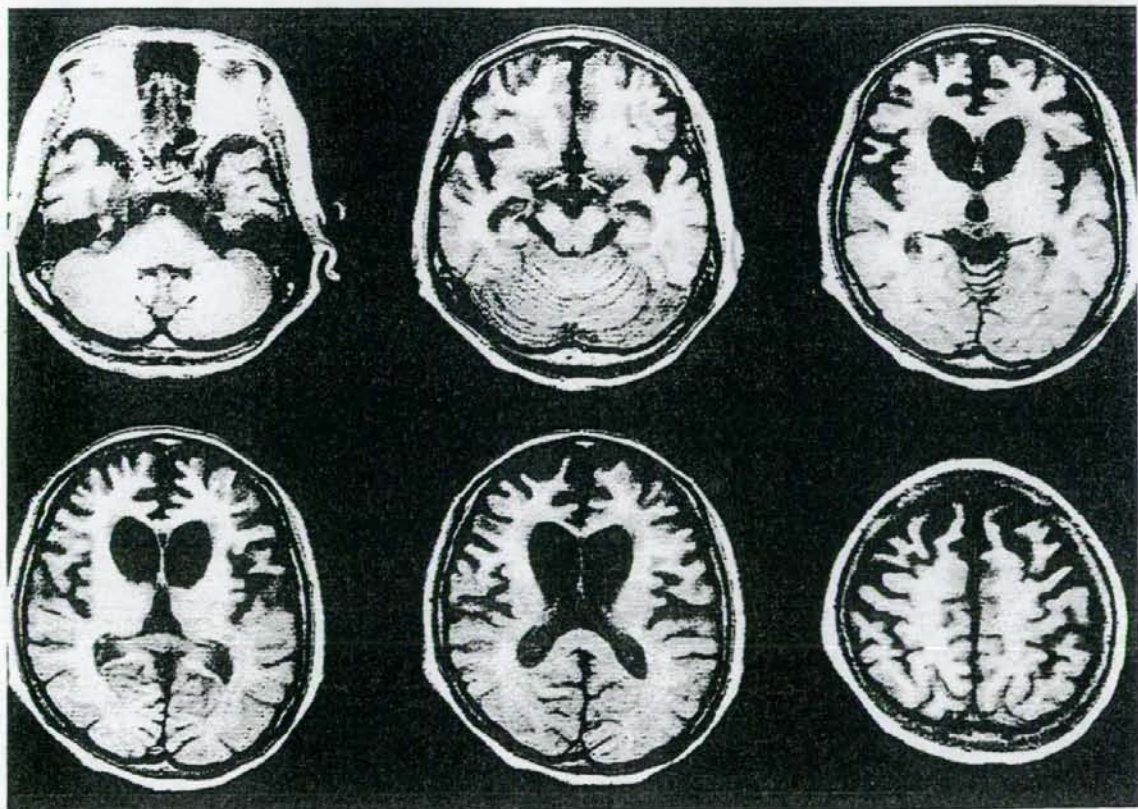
MRI performed about 1 year after the first admission. Prominent atrophy of the bilateral frontal and anterior temporal lobes can be seen.
